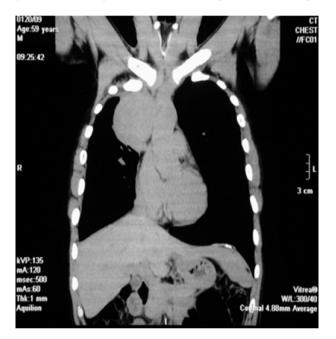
CT-chest coronal view Demonstrating mediastinal mass.
